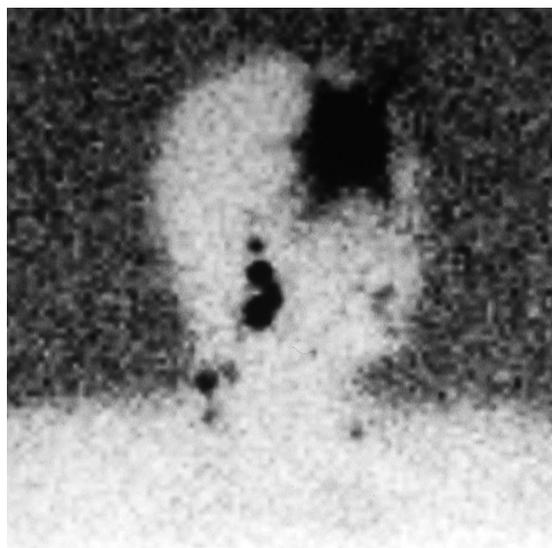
Lymphoscintigraphy demonstrates drainage to multiple nodal basins at various levels of the right neck.
